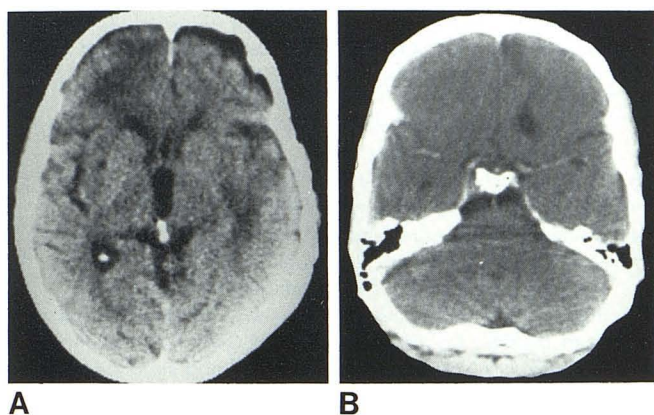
Contrast-enhanced CT in two cases of posttraumatic encephalomalacia. A, Diffuse involvement in right frontal and left temporal lobe. B, Focal involvement of inferior left frontal lobe.
